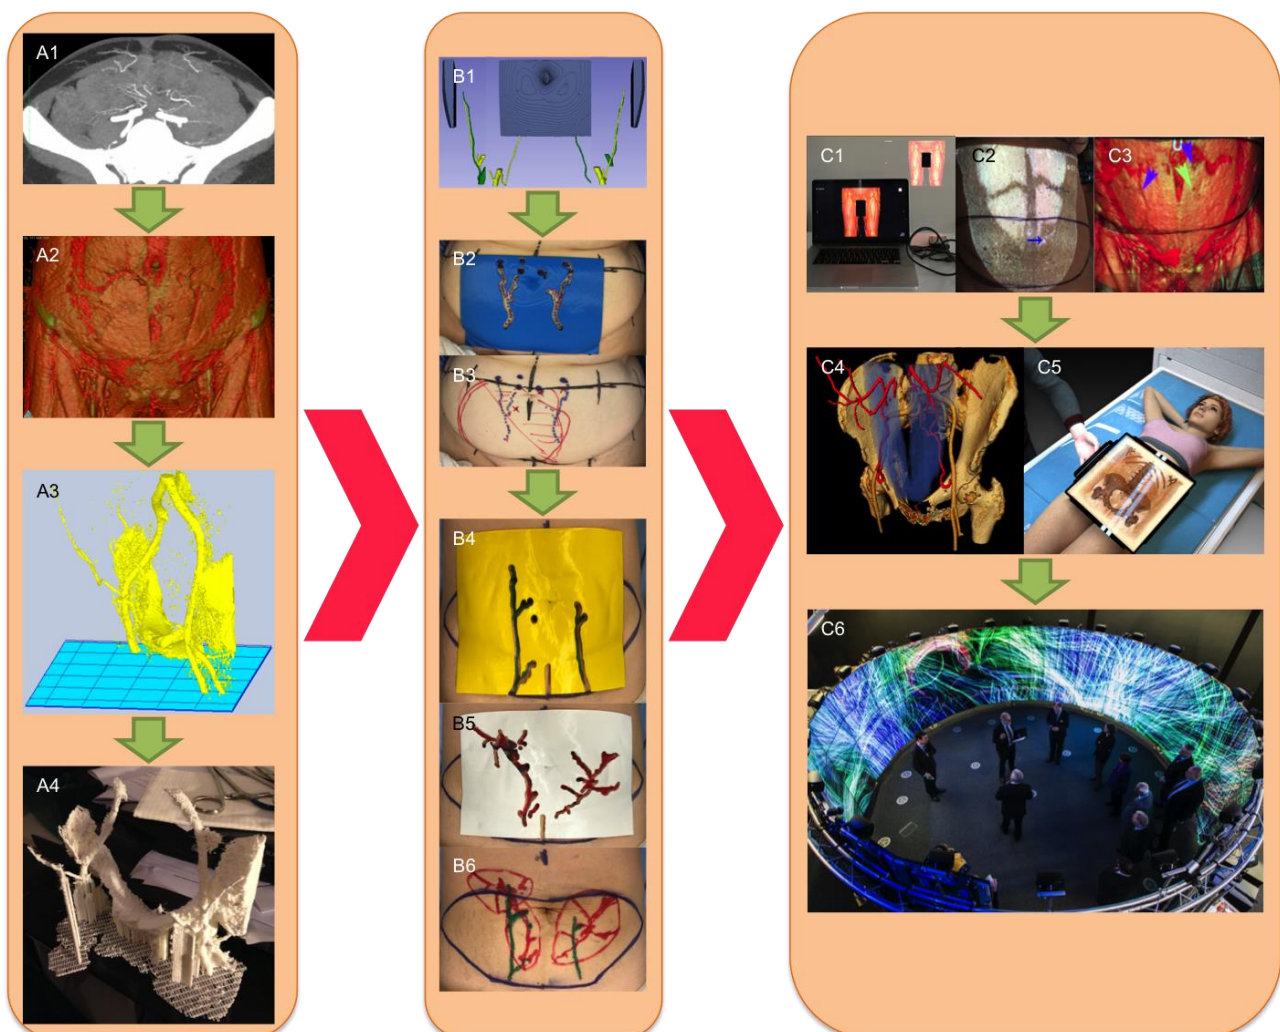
Evolution of 3D imaging and printing technique from 3D-reconstructed images and a basic 3D-printed model (A1-4) to clinically useful 3D printing application in perforator-based breast reconstructive surgery (B1-6) to advanced image analysis technology, such as augmented reality and CAVE2 facility (C1-6). (A1) 2D-reconstructed CTA image of the abdominal wall vasculature. (A2) 3D-reconstructed CTA image of the same patient in A1. (A3) Segmented image of the DIEA of the same patient in A1. (A4) 3D-printed model of the DIEA in A3. (B1) Segmented image of the abdominal wall and DIEA that spurred the idea of creating a template for preoperative planning. (B2) Patient-specific, bespoke “DIEP template” is 3D-printed and placed on the patient’s abdominal wall to help locate DIEA perforators and its pedicle. (B3) This information is used for flap designing. As 3D printing technique advanced, we are able to create both a standard DIEP template (B4) and a “perforasome template” (B5), which can additionally identify each perforasome (B6). (C1-6) Augmented reality can significantly reduce the time and labour cost involved in 3D printing by enabling direct viewing and real-time interaction with the image data. (C1) Our published direct ARC (augmented reality CTA) technique set-up using a handheld projector demonstrating 2D-reconstructed (C2) and 3D-reconstructed (C3) images on the patient’s abdomen. As technology advances, we envision that greater software processing power will enable display of greater anatomical information, such as intramuscular course of a DIEP (C4), and translation into a user-friendly, interactive platform for clinicians (C5). (C6) The latest CAVE2 facility at Monash University (Melbourne, Victoria, Australia) housing 84 million pixel stereoscopic display with powerful real-time motion tracking capability will enable interactive, seamless visualisation of relevant anatomy for preoperative planning and collaborative discussion. Reprinted with permission from Chae *et al* (37), Chae *et al* (38) and Chae *et al* (39). Abbreviations: CTA: computed tomographic angiography; DIEA: deep inferior epigastric artery; DIEP: deep inferior epigastric artery perforator.
